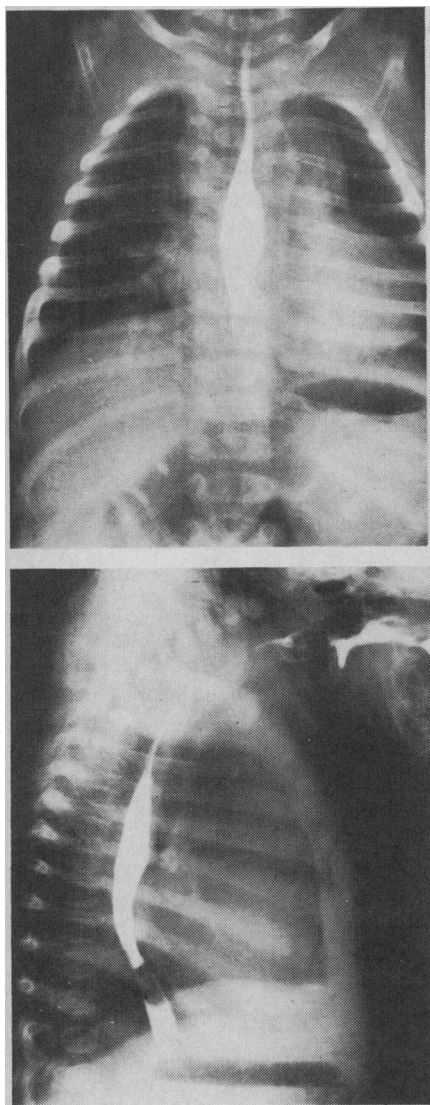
Chest roentgenogram of H.B. at 8 months of age. (a) Anteroposterior and (b) lateral views with barium swallow.
